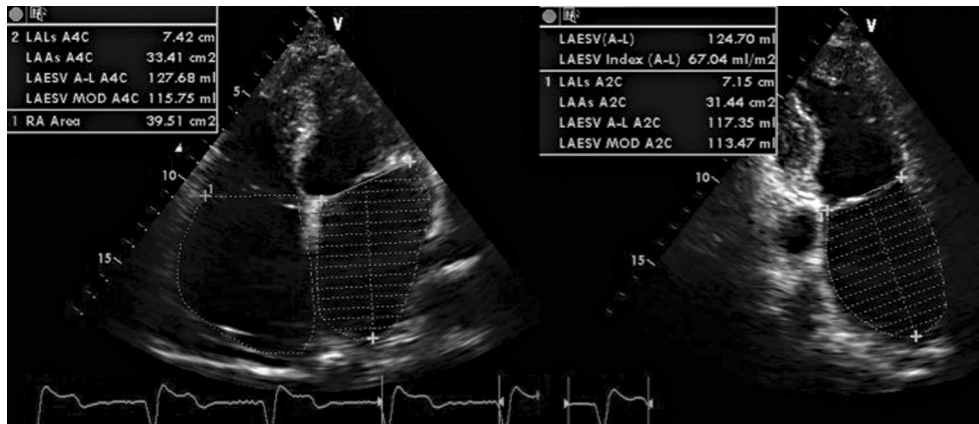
Quantification of the LA volume. This figure demonstrates the measurement of the LA volume. A frame at start of the diastole in the 2 chamber and 4 chamber view is used. The automated software of the ultrasound machine calculates the LA volume indexed to BSA.
